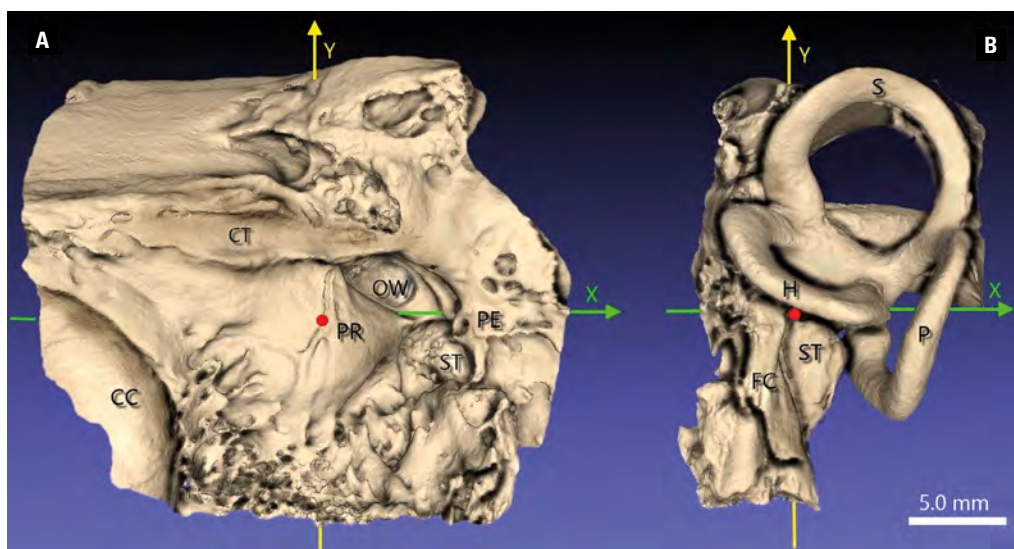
A. A three-dimensional model of the retrotympanum showing the location of the sinus tympani (ST) seen in the medial projection; CC — carotid canal; CT — canal of tensor tympani muscle; PR — promontory; OW — oval window; PE — pyramidal eminence; B. The same model rotated clockwise along the Y-axis; wall of the ST bulges posteriorly in the close proximity to the facial canal (FC) and semicircular canals: horizontal (H), posterior (P), superior (S). Orientation of the XYZ coordinate system follows as: the X-axis runs between the lower edge of the OW and the superior edge of the opening to the ST, the Y-axis corresponds to the descending portion of the FC, the Z-axis passes through the promontory (red point), perpendicularly to the X-Y axis.
